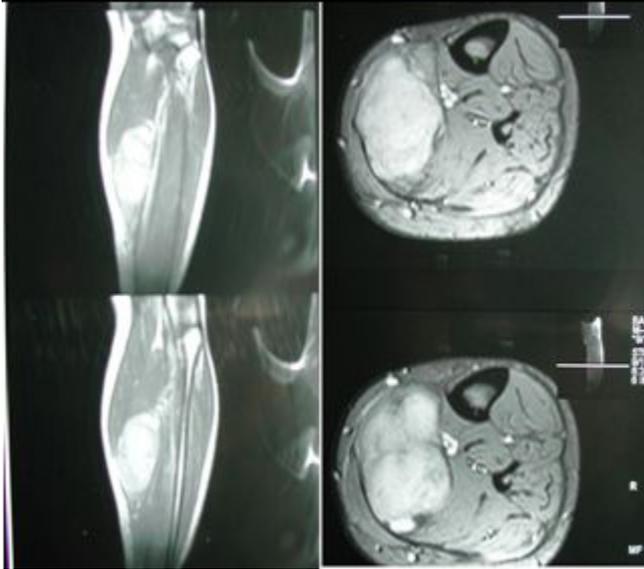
MRI imaging show intramuscular lesion in the leg.
